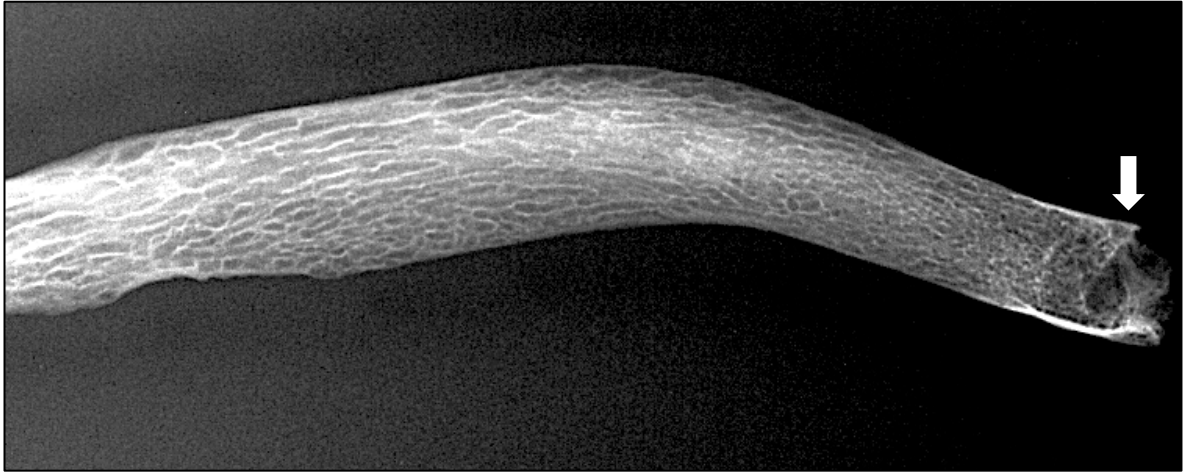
Radiographic sign strongly diagnostic for hydatids disease. Note the multilocular cystic (“bunch of grapes”) appearance (white arrow; AT-292, young adult male, Buural Uul). Image: author’s own.
